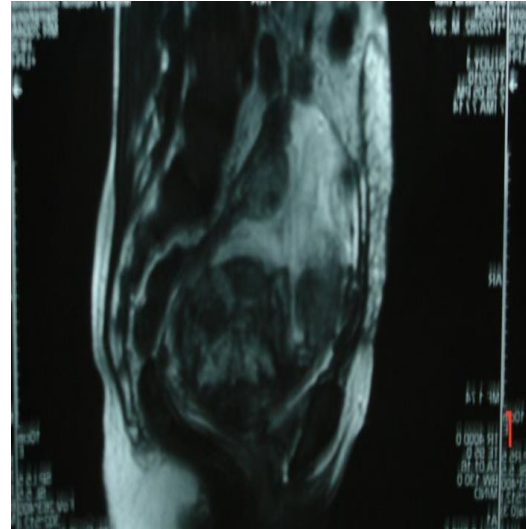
MRI showing retained placenta in Sub-total hysterectomy
